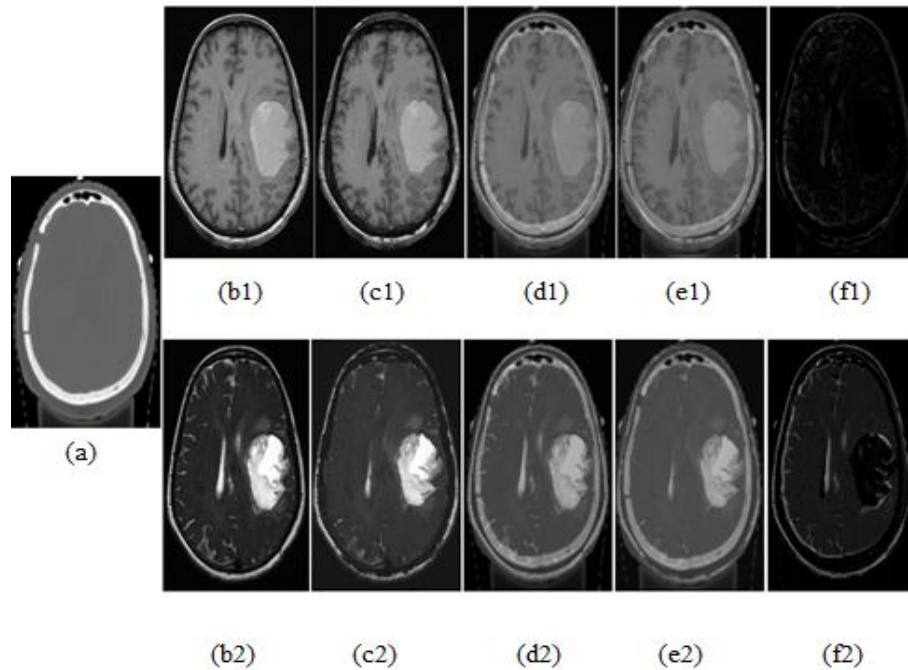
Synthetic magnetic resonance images generated by computed tomography (CT) target (a) related to specific slice: real T1w (b1), real T2w (b2), sT1w (c1), sT2w (c2), CT and T1w fused image (d1), CT and T2w fused image (d2), CT and sT1 fused image (e1), CT and sT2 fused image (e2), the image subtraction of d1 and e1 (f1) and the image subtraction of d2 and e2 (f2).
